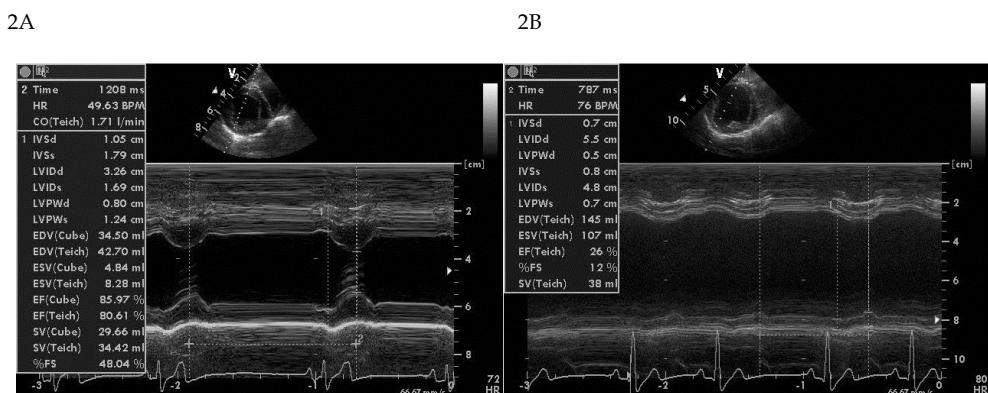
2D-M mode echocardiograms showing normal left ventricular dynamics (2A) before pacing and reduced wall motion (2B) after pacing for 12 weeks
